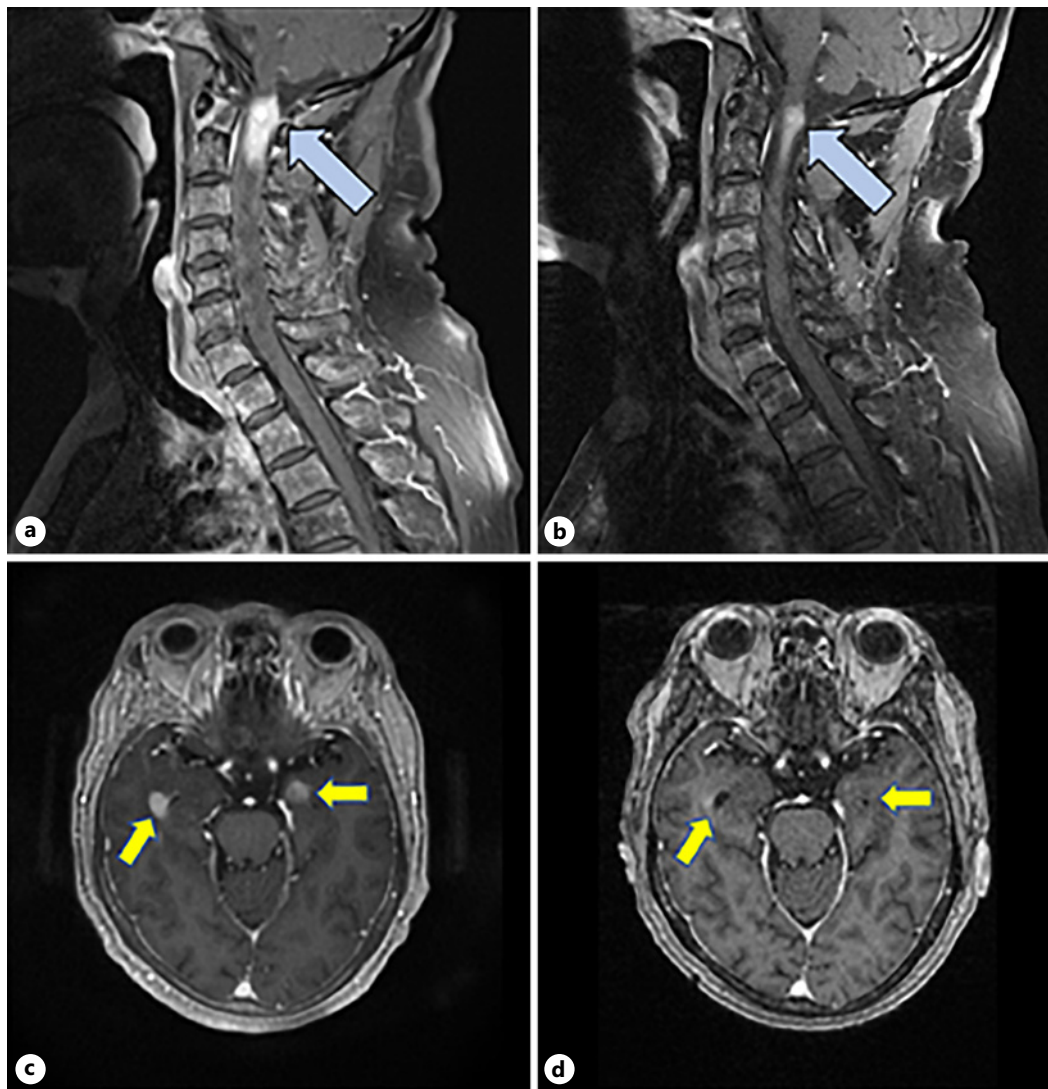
a, b Magnetic resonance imaging (MRI) of the cervical spine at initial diagnosis (a) and 2 weeks after (b) ibrutinib therapy. c, d Brain MRI at initial diagnosis (c) and 2 weeks after (d) ibrutinib therapy. Light blue arrows indicate the cervico-medullary junction mass. Yellow arrows indicate lesions in the bilateral cerebral hemispheres.
